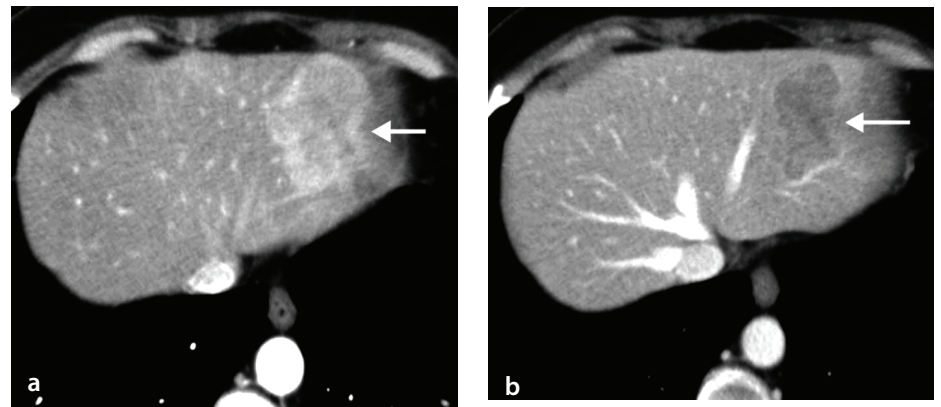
(a) Arterial phase axial computed tomography image demonstrates a hypervascular hepatic mass (arrow) at segment 2. (b) The lesion shows washout (arrow) at portal venous phase.
